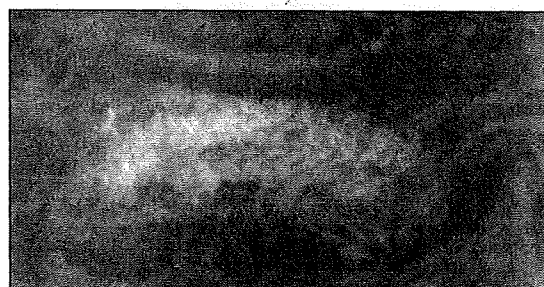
73-year-old woman with vertebral compression fracture without cleft of T7 due to osteoporosis. A, CT scan shows bone cement in epidural vein continuing to vertebral body. Cleft is not detected in fractured vertebral body. B, Lateral spinal radiograph shows opaque cement interspersed through trabecular space.
